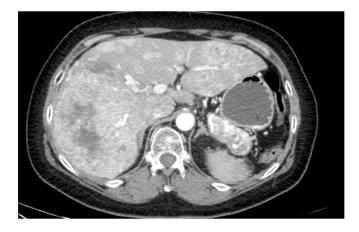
CT scan demonstrating a hypervascularized lesion of the pancreatic tail associated with multiple liver metastases
